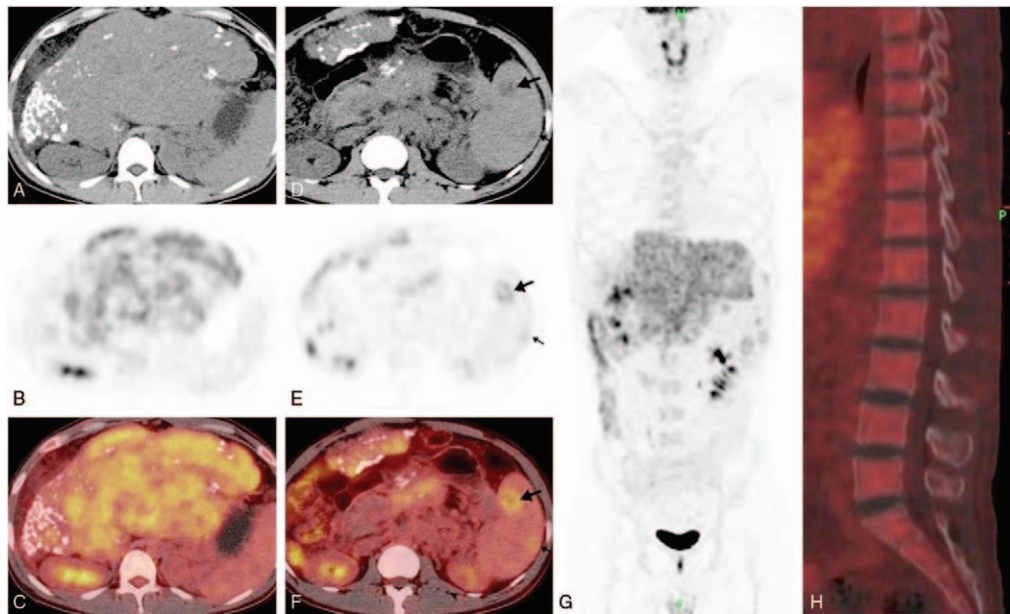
Transverse computed tomography (CT) (A), corresponding positron emission tomography (PET) (B), and fusion (C) images showing abnormally diffuse lesions with moderate fluorodeoxyglucose (FDG) uptake in the entire liver and maximum standardized uptake value (SUVmax) of 4.2. Transverse CT (D) of the spleen reveals multiple metastatic low-density lesions. Corresponding PET (E) and fusion (F) images show peripheral rim FDG uptake with SUV max of 3.6. The maximum intensity projection PET (G) mainly displays diffuse lesions in the liver and multiple nodular splenic lesions. Spinal sagittal fusion image (H) showing normal morphology preoperatively.
